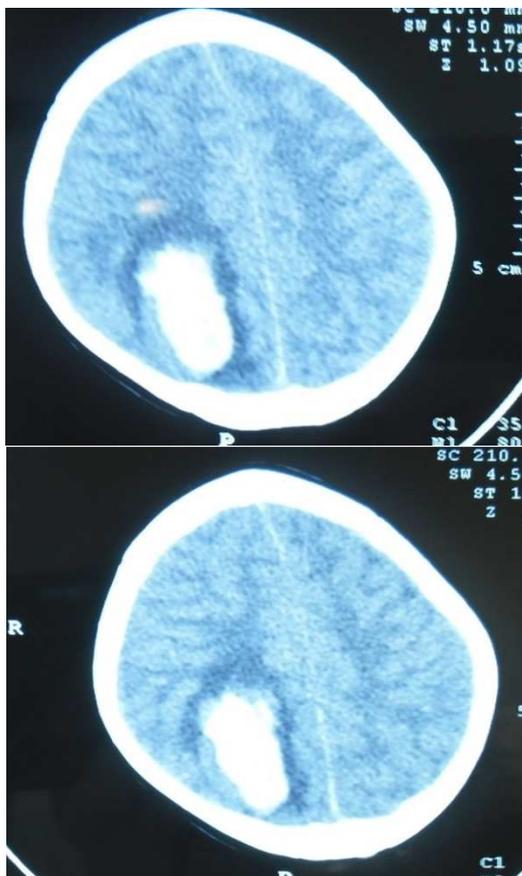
CT scan at admission showing a blood clot with mass effect on the surrounding structures
